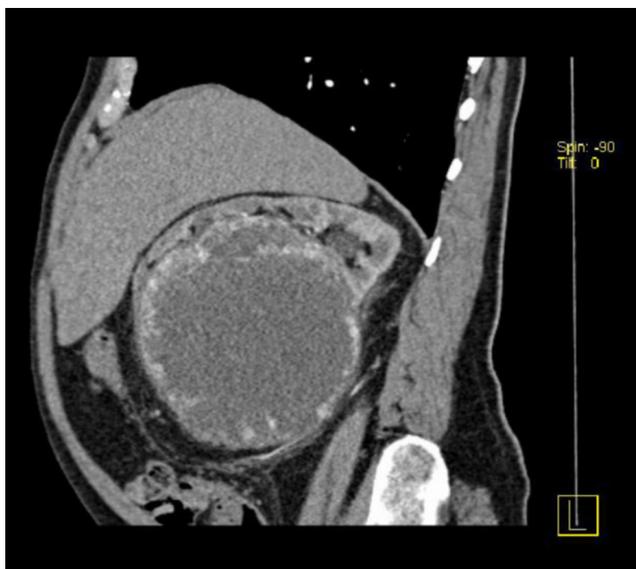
70-year-old male with renal mass. Coronally reformatted CT again demonstrates a large mass involving the mid and lower poles of the right kidney and elevating the liver.
